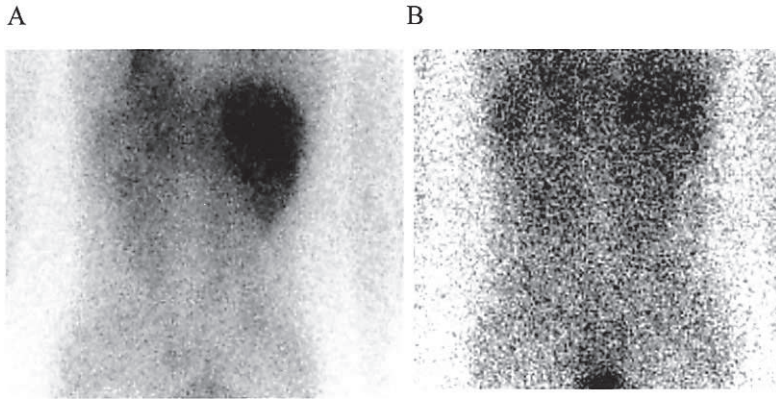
A: 6 hours, B: 24 hours. ^{123}I -MIBG scintigraphy showed no abnormal uptake in bilateral adrenal glands.
